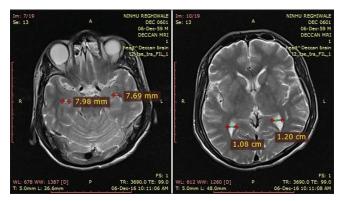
Magnetic resonance imaging of 57 yr old female showing temporal and occipital horn horizontal diameter
